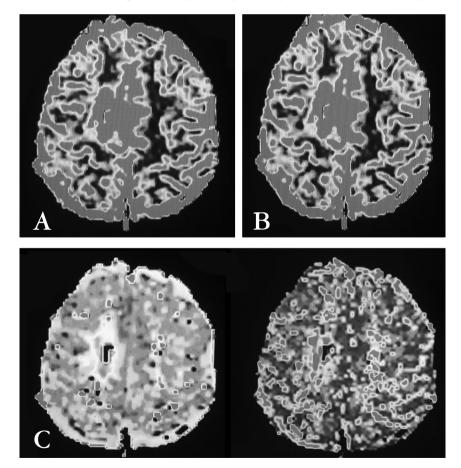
Perfusion magnetic resonance imaging maps demonstrate increased signal intensity in cerebral blood flow (A), cerebral blood volume (B), mean transit time (C) and time-to-peak of both developmental venous anomaly and surrounding parenchyma.
